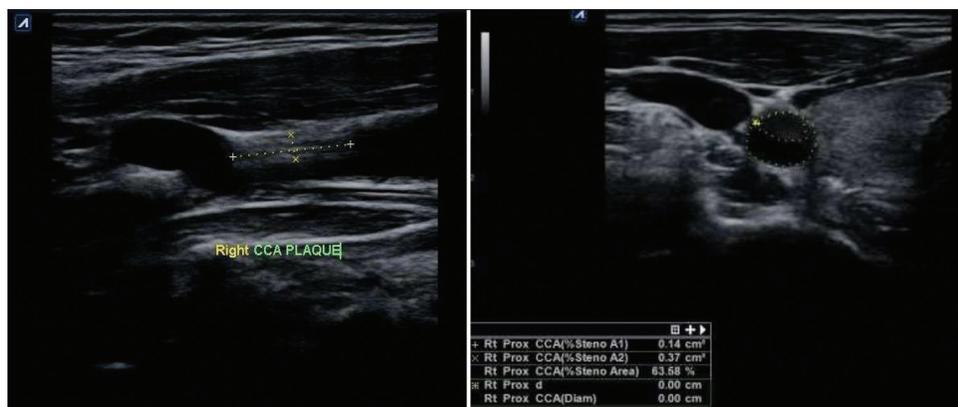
In same patient longitudinal and transverse grey scale ultrasound images of right carotid artery shows hyperechoic plaque in right common carotid artery causing significant 63% stenosis
